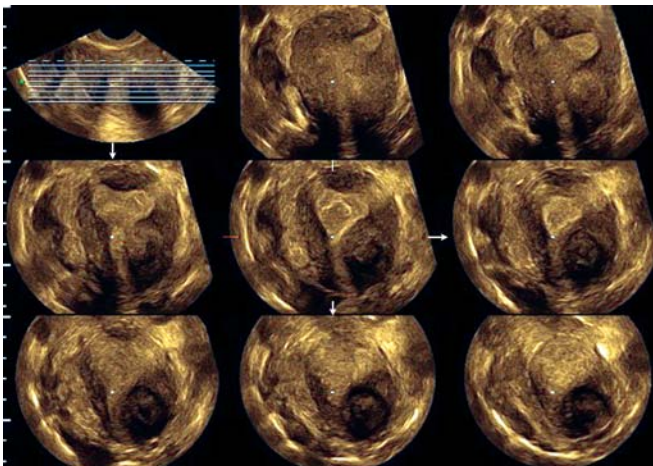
Tomographic ultrasound imaging demonstrates a lesion in multiple parallel planes. This makes it a useful modality for a more accurate delineation of the location of fibroids as shown in this entirely interstitial fibroid
